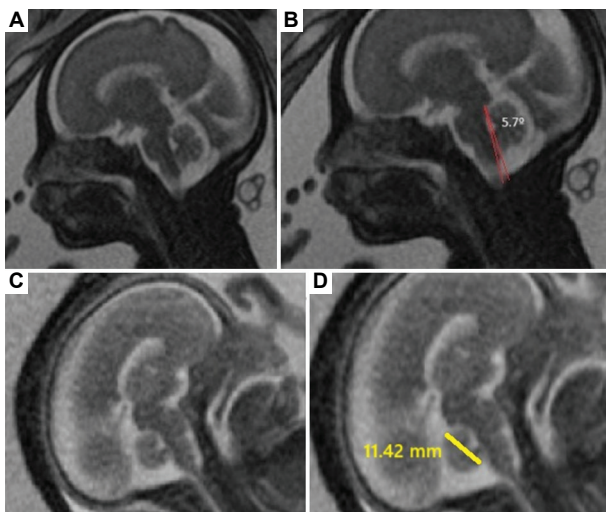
Normal MRI images. (A and B) Sagittal TRUFI MRI images of a 30-week fetus depicting the relationship between the brainstem and vermis, vermian lobulation, and the tegmentovermian angle. (C and D) Sagittal TRUFI MRI images of a 22-week fetus showing the craniocaudal diameter of the vermis.
